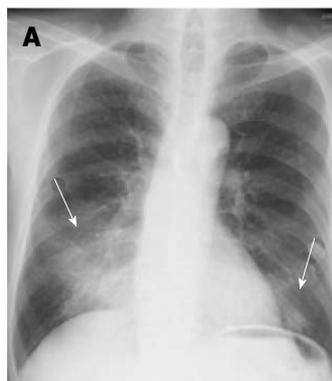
Exogenous lipid pneumonia in a woman in her 30s: Courtesy of Dr. Kazuhiro Suzuki, an attending radiologist, at the department of Radiology, Juntendo University School of Medicine. This patient had been taking petrolatum (paraffin) for intractable constipation. The presence of lipid was confirmed by transbronchial lung biopsy. A: Chest radiograph shows bilateral consolidations in the lower lung fields (arrows); B: Thin-section CT demonstrates an area of clearly demarcated ground-glass opacity with a subpleural consolidation (arrow); C: Chest computed tomography (CT) with a mediastinal window setting reveals the subpleural consolidation to be of fat attenuation (arrow, mean CT value -45HU).
